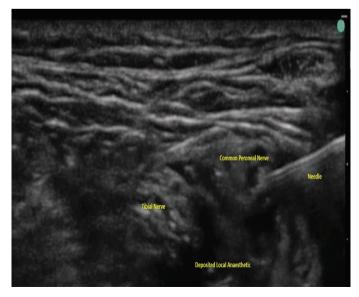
Ultrasound image of the nerve block
